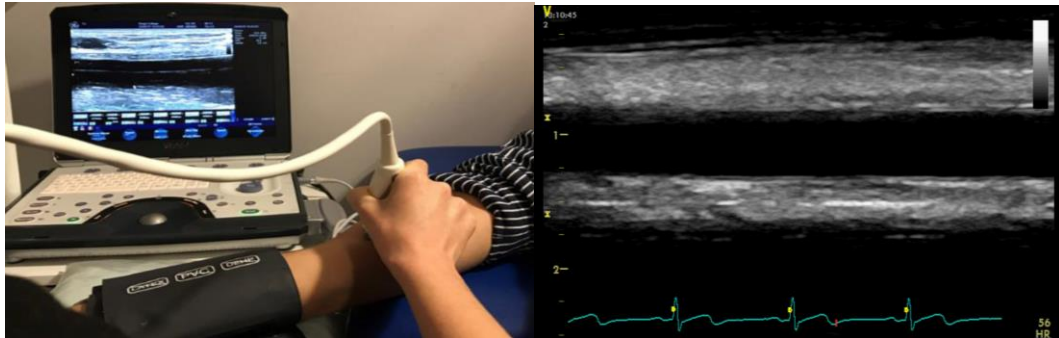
Flow-mediated dilation measurement and ultrasound image of the brachial artery.
